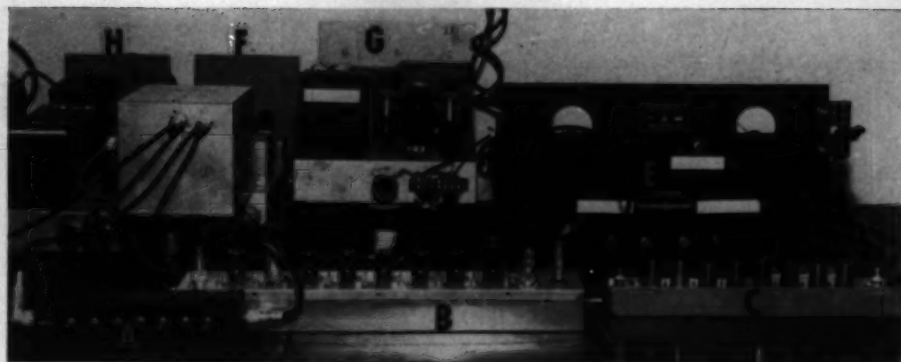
(Baum and Greenwood). Detailed view of ultrasonic locator.
